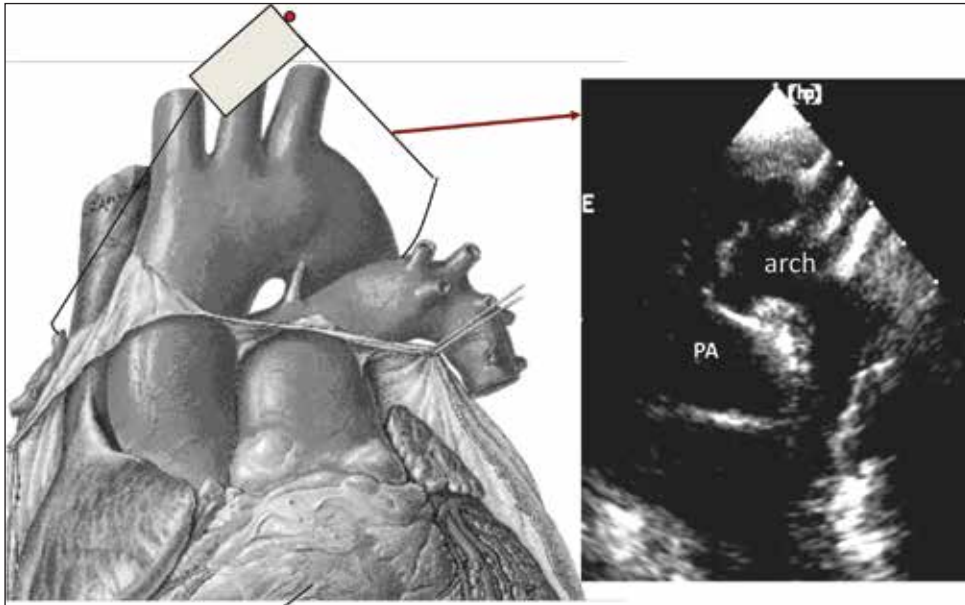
Transducer position and imaging planes for the supra-sternal long-axis views (left). Echocardiogram showing the structures seen in the supra-sternal long-axis view (right). PA: pulmonary artery, Arch: Aortic Arch
